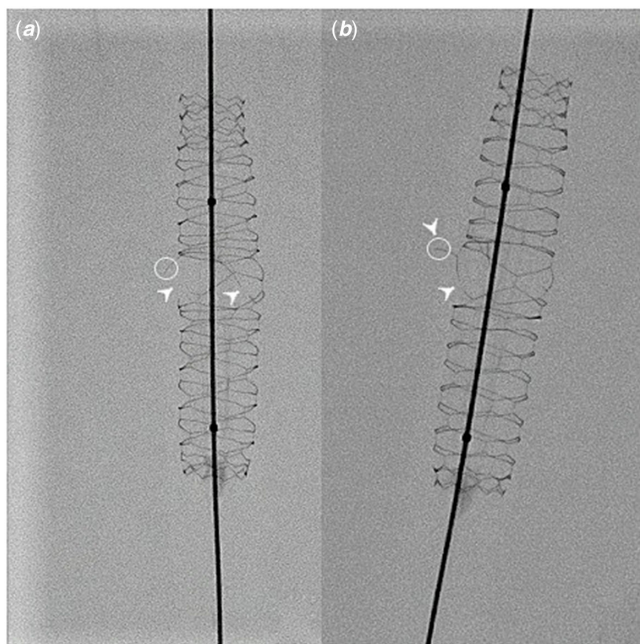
Anteroposterior (a) and lateral (b) X-ray acquisitions shots of the BeSmooth $\text{\O}10 \times 23$ mm after progressive expansion with an Armada 35 balloon $\text{\O}14$ mm. Note the two longitudinal fracture lines within the stent occurring in two opposing cells within the most stretched middle section of the stent at a diameter of 13 mm (white pointed arrows). This pattern of fractures induced an outward orientation of the stent struts in different directions (white circles).
